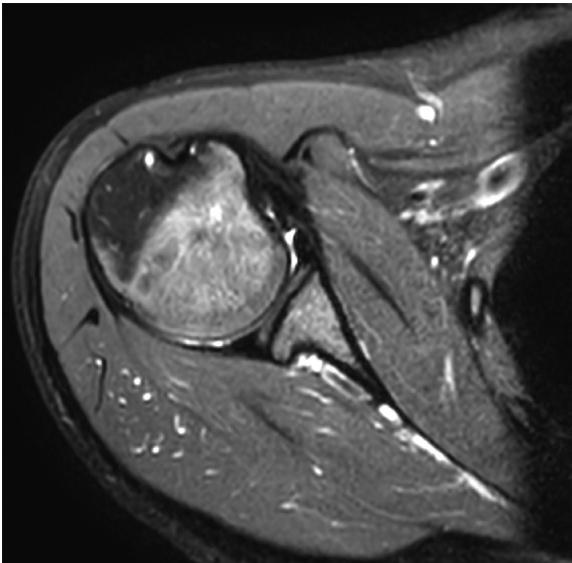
Axial magnetic resonance image of a patient with functional shoulder instability and associated glenoid dysplasia with convex shape of the articular surface of the glenoid.
